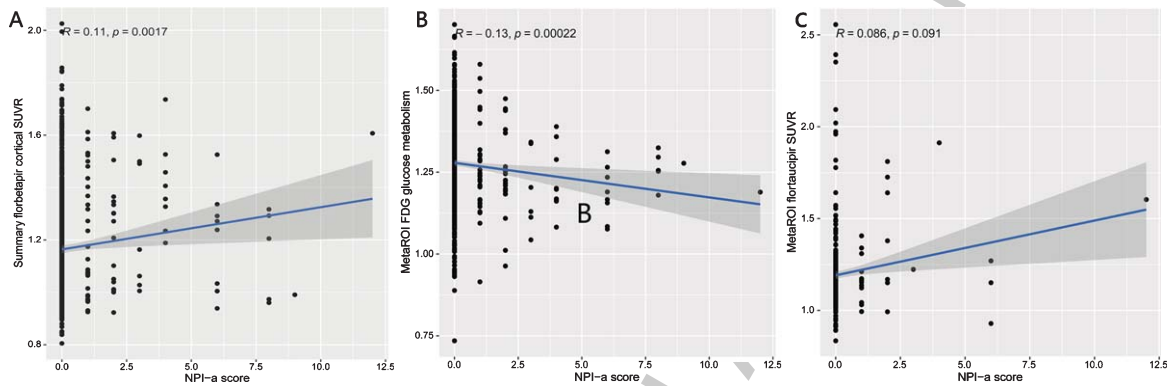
Cross-sectional association between A β PET SUVRs, FDG PET values, tau PET SUVRs, and NPI-a score at baseline. NPI-a had a positive relationship with AV45 PET SUVRs. NPI-a had a negative relationship with FDG PET values. There was no significant relationship between NPI-a and tau PET SUVRs. NPI-a score, anxiety score from Neuropsychiatric Inventory (NPI).
